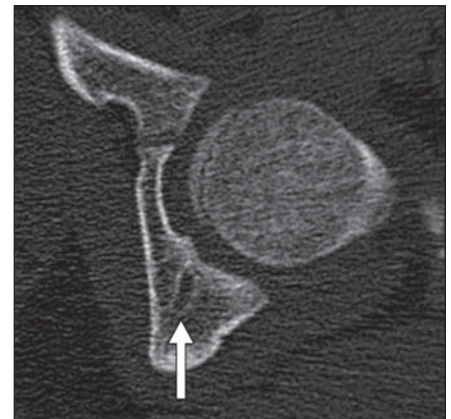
11-year-old boy with tubular tracking. Axial CT image in bone window shows characteristic appearance of tubular structure (arrow) with thin sclerotic borders without periostitis or cortical changes.
